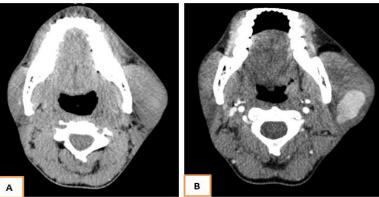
Cervical CT, without and with contrast medium, axial sections: Oval formation of the left parotid lodge, spontaneously sparse (A), and heterogeneously taking the contrast (B)
